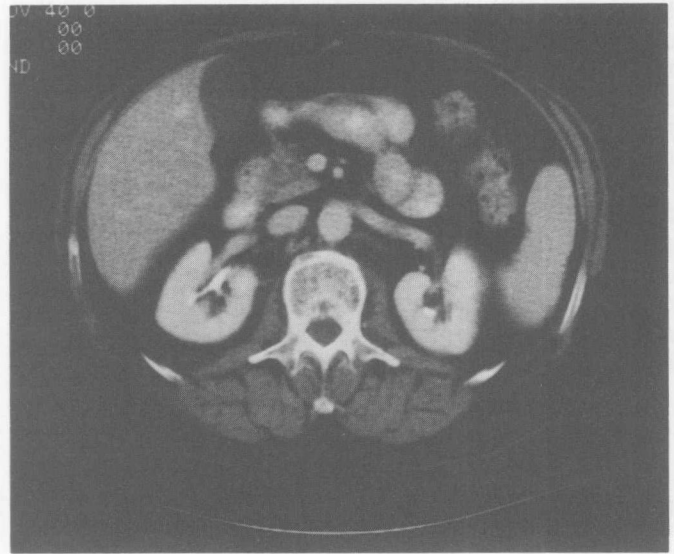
A CT scan at the level of L1 showing the position of the kidneys lying in the paravertebral gutters. (By courtesy of Professor I. Isherwood, Department of Diagnostic Radiology, University of Manchester.)
